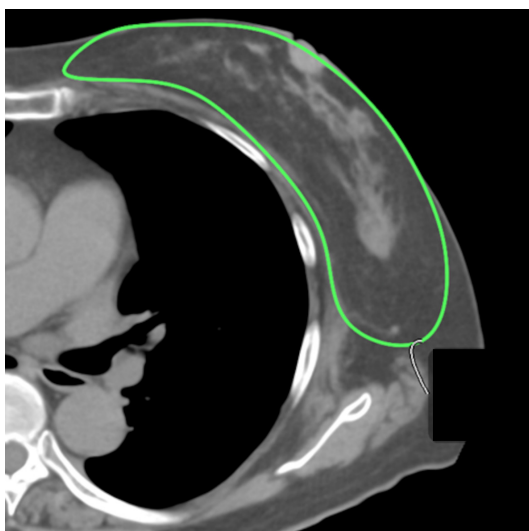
Measurement of the breast using CT. The margins of the sectioned breast image were traced in each slice (Figure 2), and the breast volume was calculated by summing the values of the traced area and multiplying by a section interval of 5 mm
